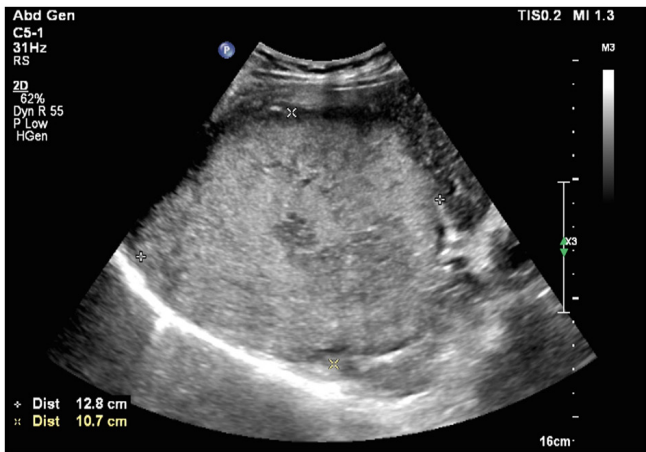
Case 1: Ultrasound image of the liver. A large hyperechoic mass was identified in the right lobe of the liver, measuring ~12.8x12.8x10.7 cm, with ill-defined borders and heterogeneous internal echotexture.
